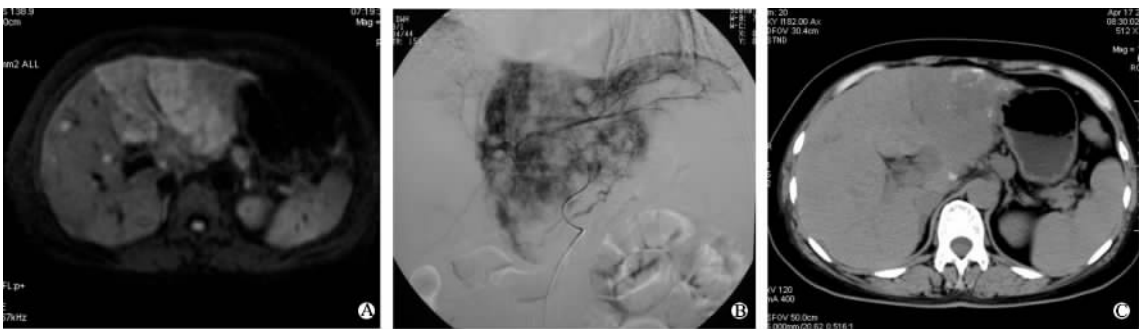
肝癌 TACE 术后无或少许碘油沉积病灶的 DWI、DSA 和 CT 图像特征
